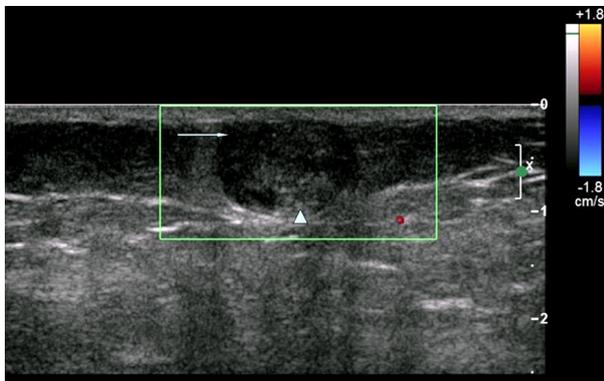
Ultrasonography revealed a 1.8×1.0 cm sized, well defined, ovoid, heterogenous mass in the subcutaneous layer without vascularity, and the mass consisted of a hypoechoic cystic portion (arrow) and hyperechoic solid portion (arrowhead).
